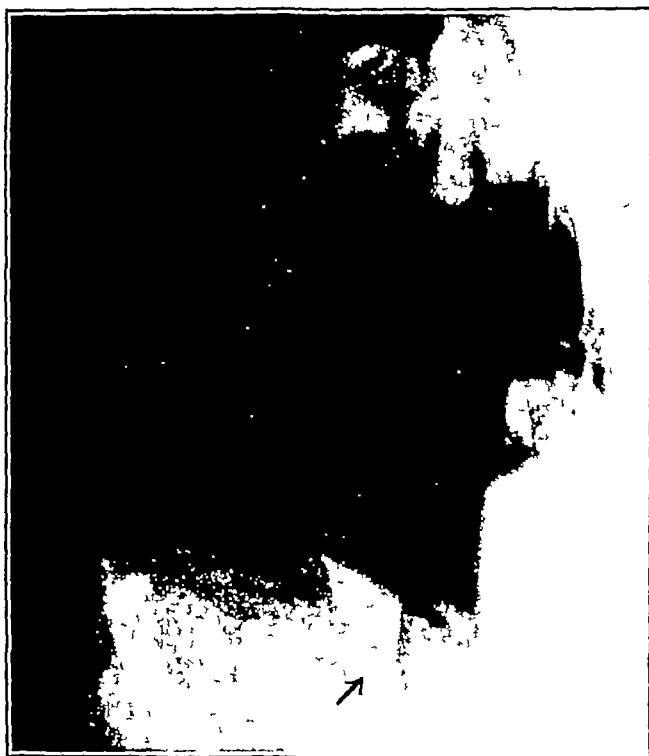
Case H C Roentgenogram showing gap in right side of mandible
